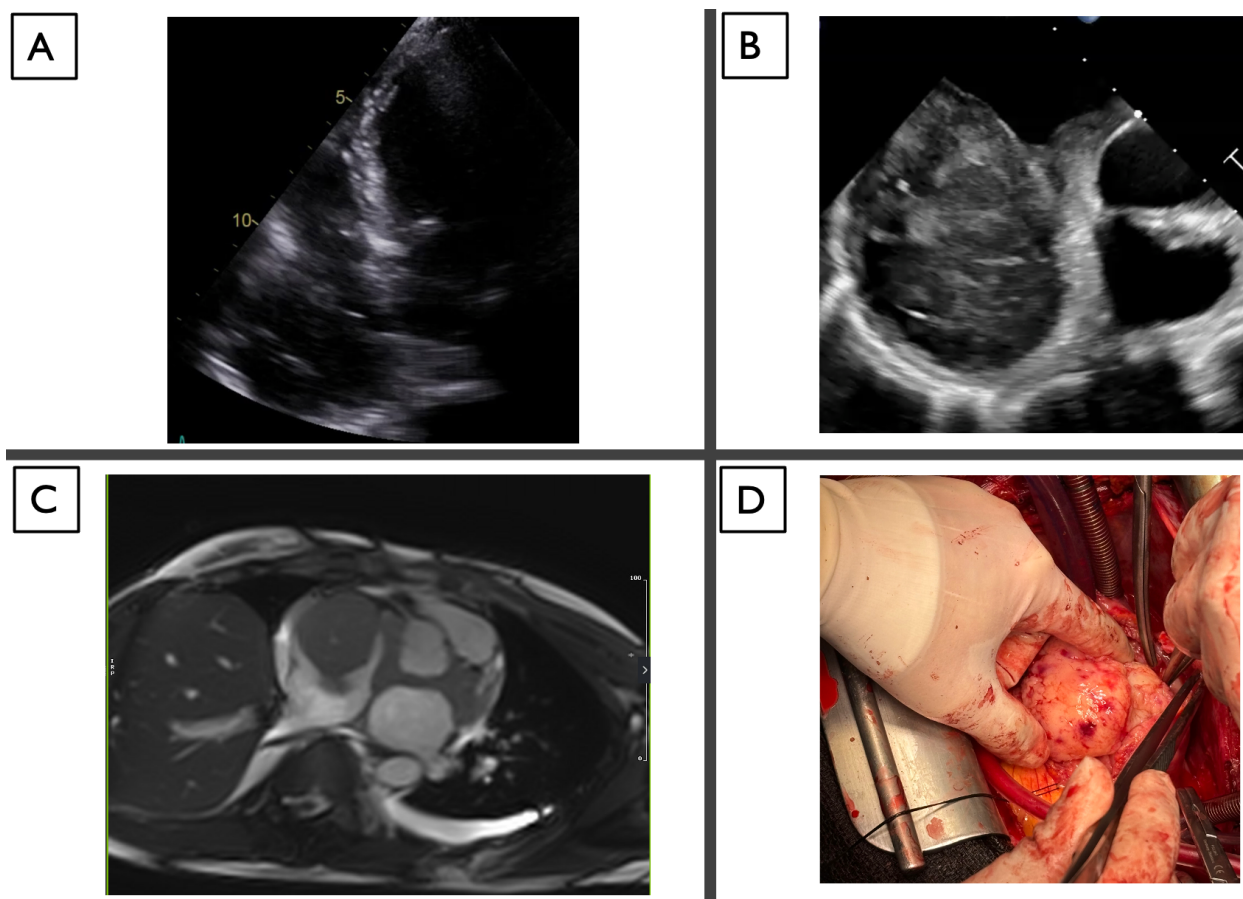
A. Right chamber cavity focused view by transthoracic echocardiogram; B. Right atrium by transesophageal echocardiogram; C. Axial view of right atrium and aortic root with tumor involvement by cardiac MRI; D. Macroscopic pathology of right atrial mass peri-op.
